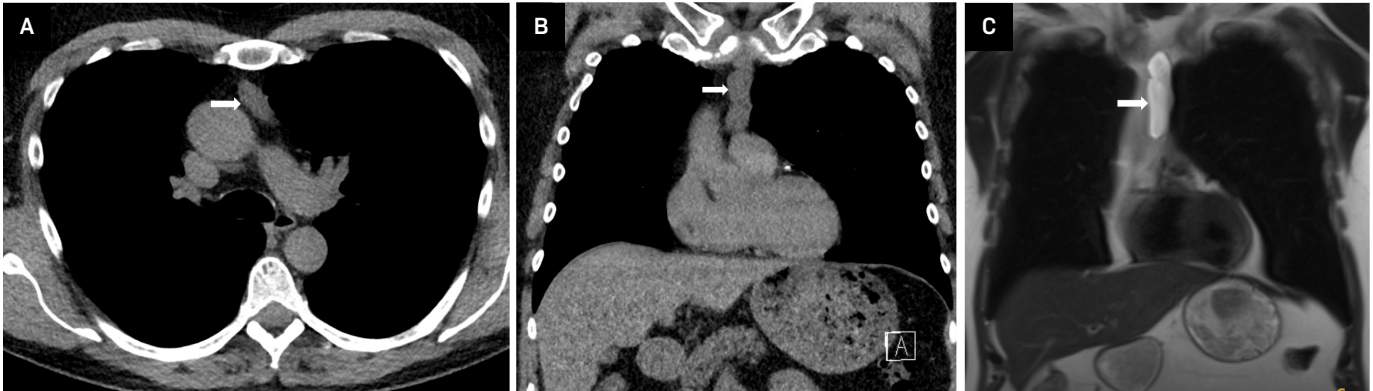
Lymphangioma. (A, B) Axial and coronal T2-weighted MRI sequences showing a T2 hyperintense visceral mediastinal lesion abutting the pulmonary artery, which represents lymphangioma.
